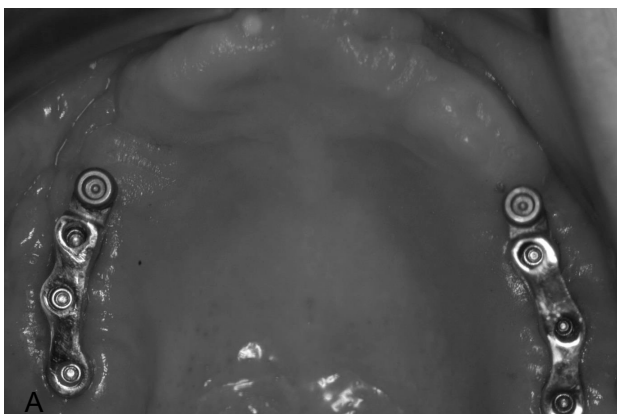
a, b. Clinical and X-ray of posterior implant position.
